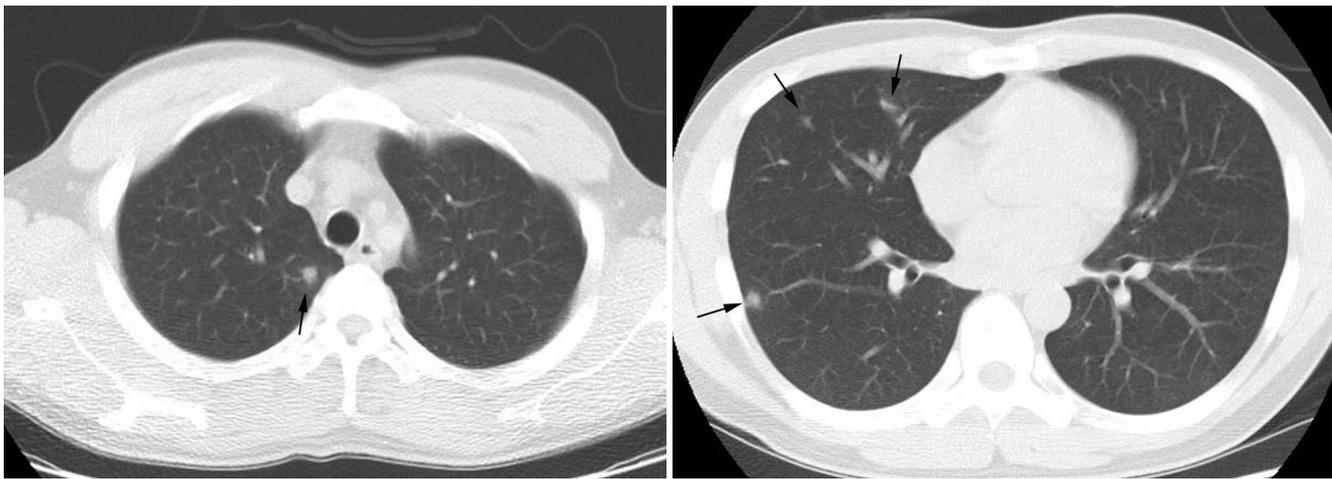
A 43-year-old man with simple pulmonary eosinophilia. The laboratory findings show peripheral blood eosinophilia (1546/μL) and a positive stool test for clonorchiasis sinensis. Low-dose CT shows ill-defined nodules (arrows) in right lung (A, B). All lesions disappeared on the CT obtained 25 days later.
